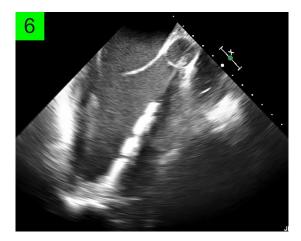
Intraoperative TEE demonstrating successful placement of the PROTEK Duo[®] cannula within the left heart with inlets positioned centrally within the left ventricular chamber and outflow inlets positioned in the aortic root, above the aortic valve. TEE, transesophageal echocardiogram
